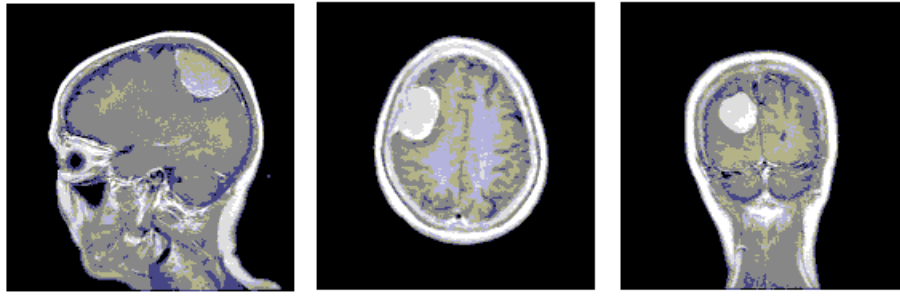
Brain MRI slices captured from different directions [6]
